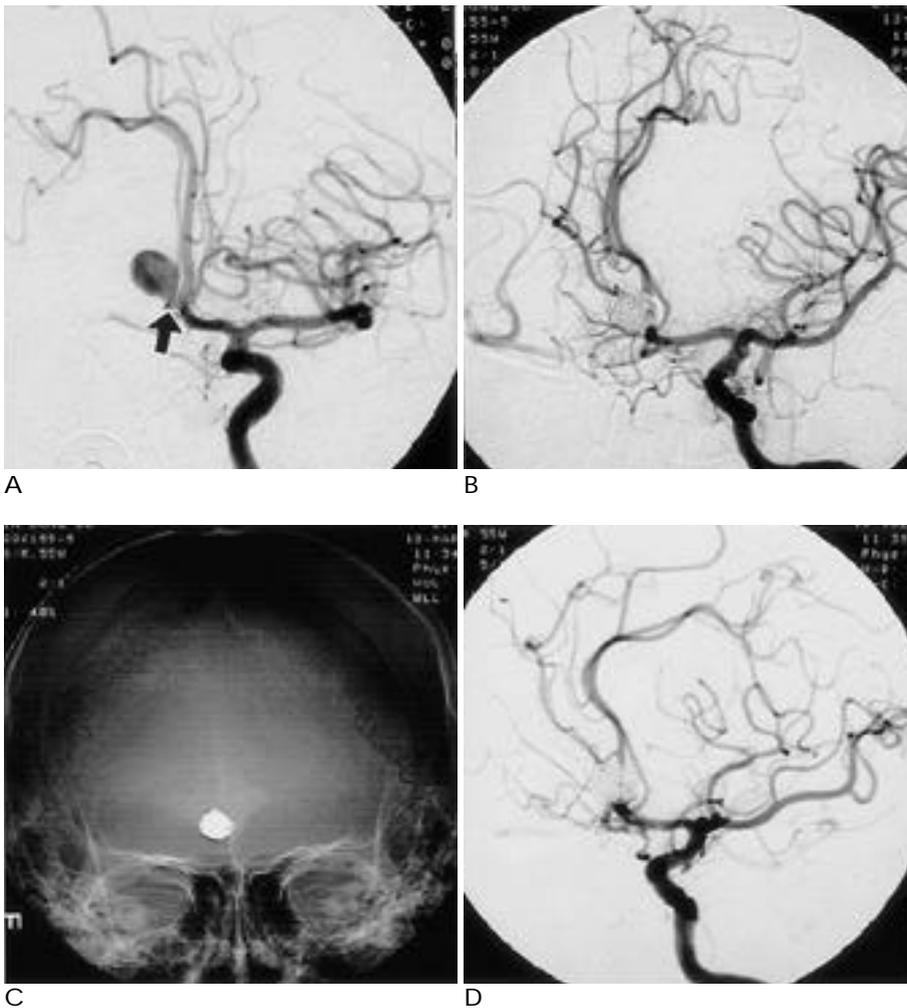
A fifty-seven-year-old man with unruptured aneurysm (case 2). Left internal carotid angiogram before embolization (A) shows an aneurysm arising from the anterior communicating artery of the opposite side and a short segment of the anterior communicating artery is visualized (arrow). The aneurysm was superselected via the left internal carotid, left anterior cerebral and anterior communicating arteries. The lesion was treated with GDC-10 and entire portion of the sac was occluded (B) with preservation of the anterior communicating artery. Densely packed coil mass is seen on plain radiography after treatment (C). Follow-up angiogram 12 months after treatment (D) shows stable result without any change of coils.
